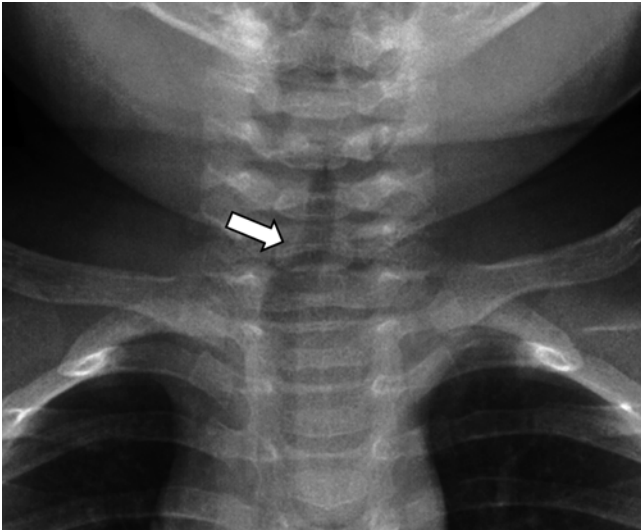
An 18-month-old boy who underwent chest radiograph for evaluation of pneumonia in the setting of fever and elevated white blood cell count. Frontal chest radiograph demonstrates normal deviation (*arrow*) of the trachea to the right of midline at the thoracic inlet level
